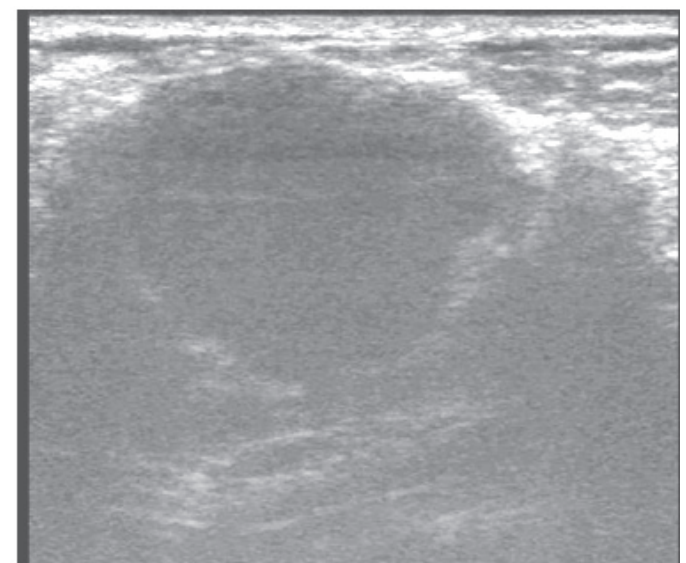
Left axillary ultrasound showing a large lymph node with architectural distortion. The left axillary lymph node measured 3x2.8 cm in size on transverse view on its widest diameter.
